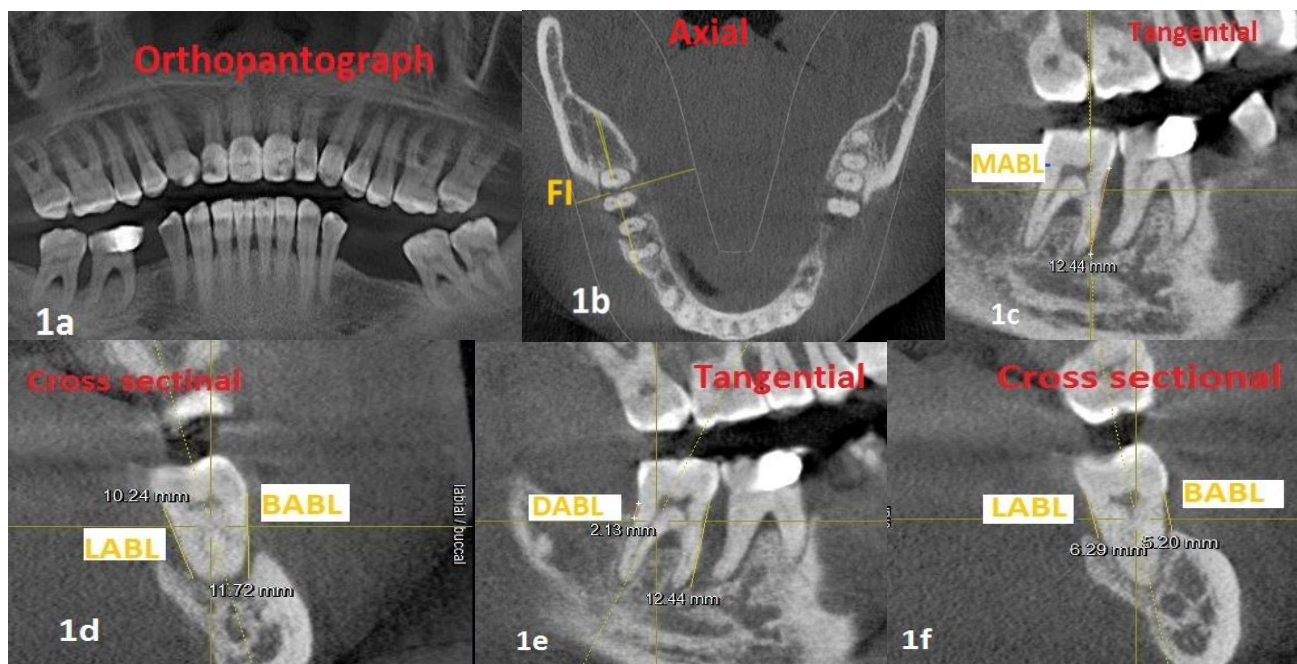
1a- OPG view of a patient with periodontitis revealing different level of bone loss. 1b CBCT, axial view showing furcation involvement, 1c- CBCT, is the tangential view showing amount of bone loss on the mesial root (12.44 mm), 1d- CBCT, is the cross sectional view showing amount of bone loss on the buccal and lingual root (11.72mm,10.24mm respectively), 1e- CBCT, is the tangential view showing amount of bone loss on the distal root (2.13mm). 1f- CBCT, is the cross-sectional view showing amount of bone loss on the buccal and lingual root (5.20 mm, 6.29 mm) respectively.
